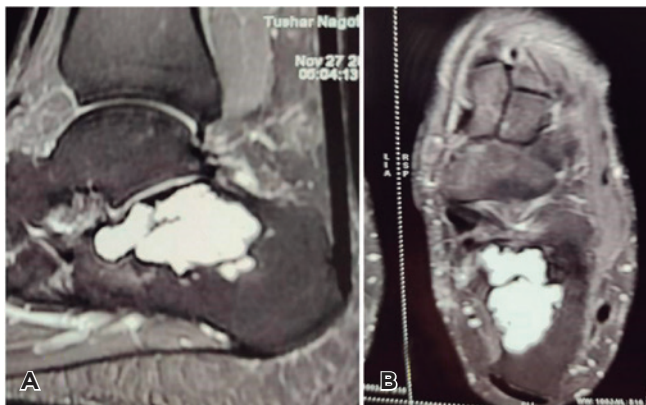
MRI T2 weighted image. A) Sagittal. B) Axial sections suggest well-defined, expansile, sub-articular, eccentrically hyperintense lesion in the body of calcaneum with minimal blood fluid levels at subtalar joint.
